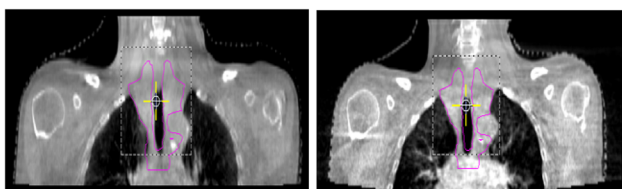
A pair of CBCT images with the default (on the left) and the modified (on the right) to reduce dose by a factor of 2.7 for comparison in H&N clinical scenario.
